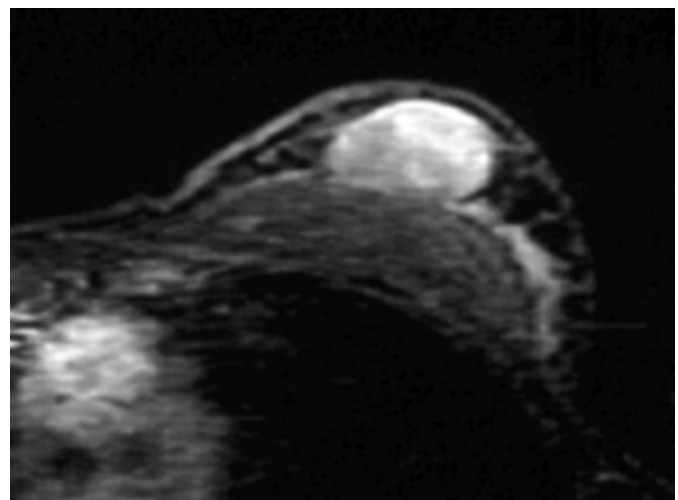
MRI (axial MPR of the left breast): oval mass with regular margins and marked inhomogeneous enhancement. Well evident cleavage plane with pectoral muscle.
